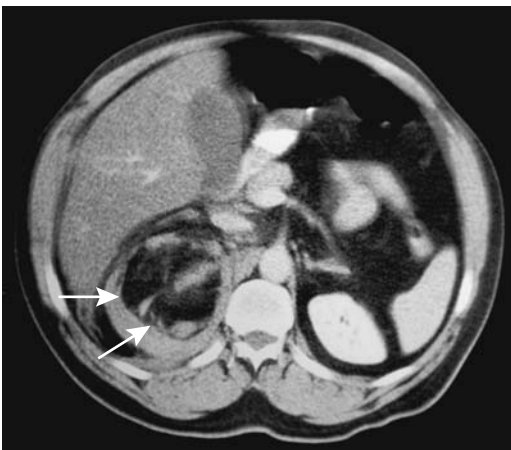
Bleeding adrenal myelolipoma. Contrast-enhanced CT reveals a fat-containing tumor superior to the right kidney (arrows). Angiography performed shortly after this study identified a hypovascular tumor. (Courtesy of Patrick Fultz, M.D., University of Rochester.)
